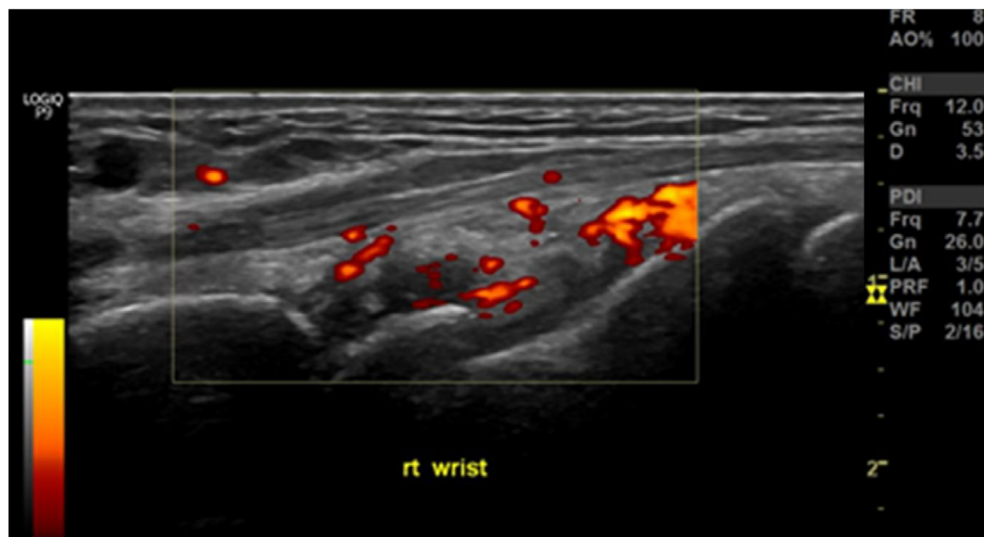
Power Doppler ultrasound (PDUS) signals of the right wrist of a 47 years female rheumatoid arthritis patient.
